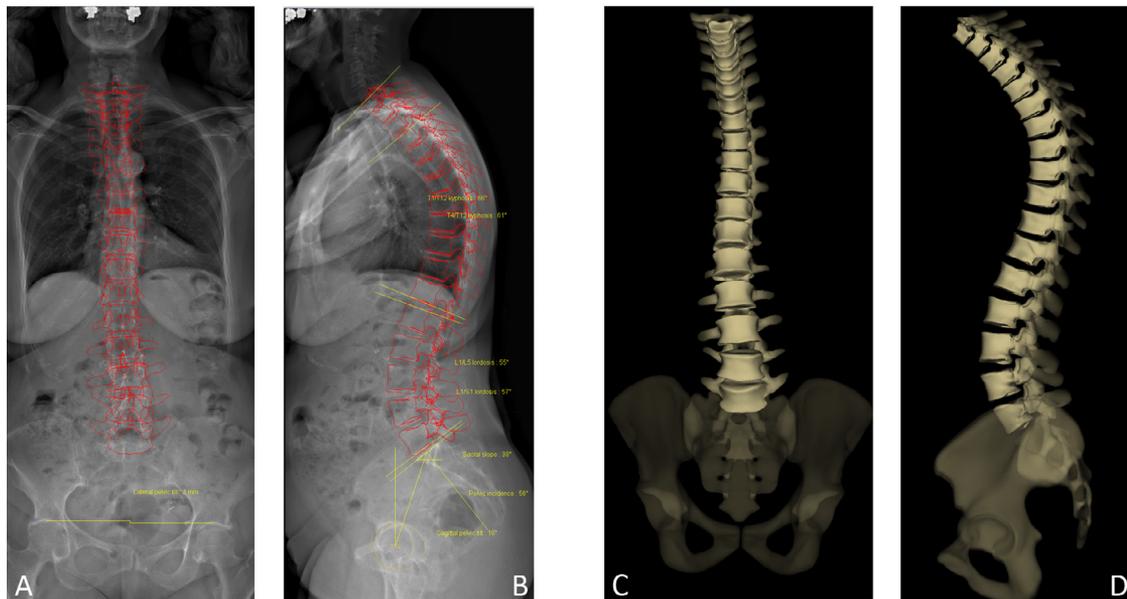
Spine model reconstruction performed through sterEOS software for a female subject, overlaid over the frontal (A) and lateral (B) radiographic images simultaneously acquired with the EOS system. The anatomical parameters' values are reported as well. The (C) and (D) pictures depict the corresponding 3D spine model.
